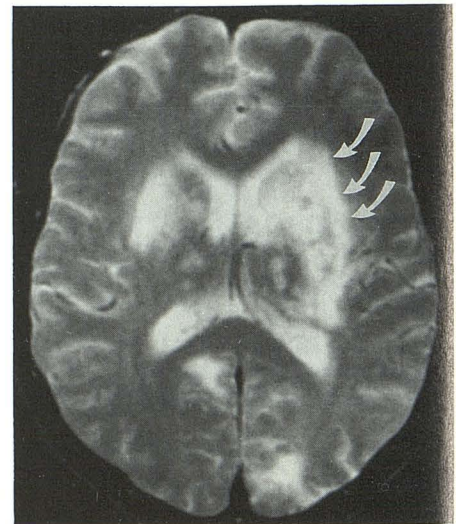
Case 7: 29-year-old man with positive toxoplasmosis titers combined with a malignant lymphocyte profile on CSF analysis. Axial T2-weighted MR image (2000/80) shows hyperintense lesions involving basal ganglia, with left greater than right (arrows). Notice involvement of internal capsules; left external and extreme capsules with involvement of insular cortex. Although this patient's serology was positive for toxoplasmosis, his CSF demonstrated evidence of malignant lymphocytes secondary to primary CNS lymphoma. This case emphasizes the importance of doing a biopsy of a mass lesion to differentiate toxoplasmosis from primary CNS lymphoma.
